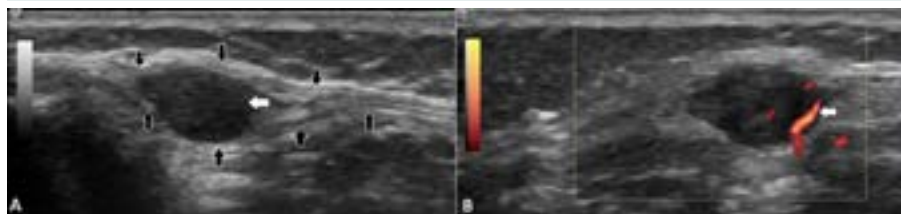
(A, B) Longitudinal sonograms of right knee show a well defined oval homogeneously hypoechoic lesion with eccentric prominent vascularity (white arrows) in the deep soft tissue of medial aspect of anterior knee. The lesion is seen within and splitting the medial retinaculum (black arrows)
